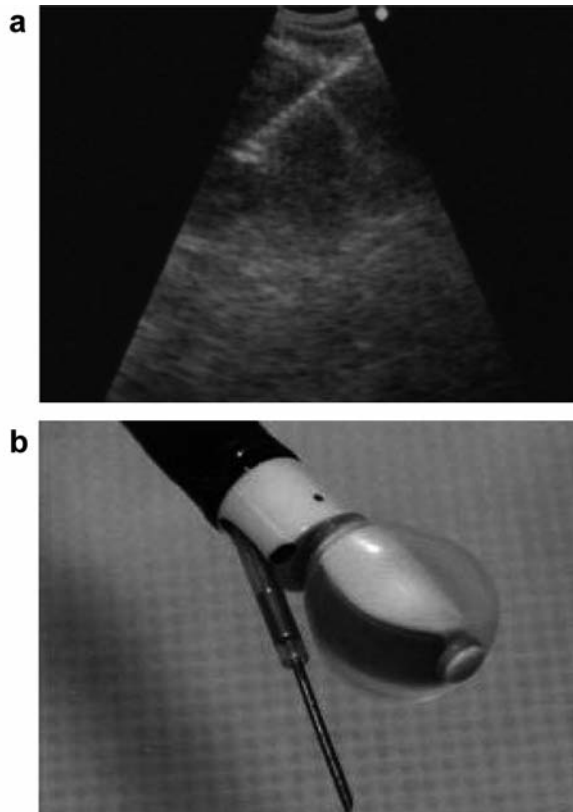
A: Ultrasound image with real-time puncture of a subcarinal lymph node. B: Endobronchial ultrasound bronchoscope with inflatable balloon for maximization of contact with the bronchial wall and 22-gauge needle.
